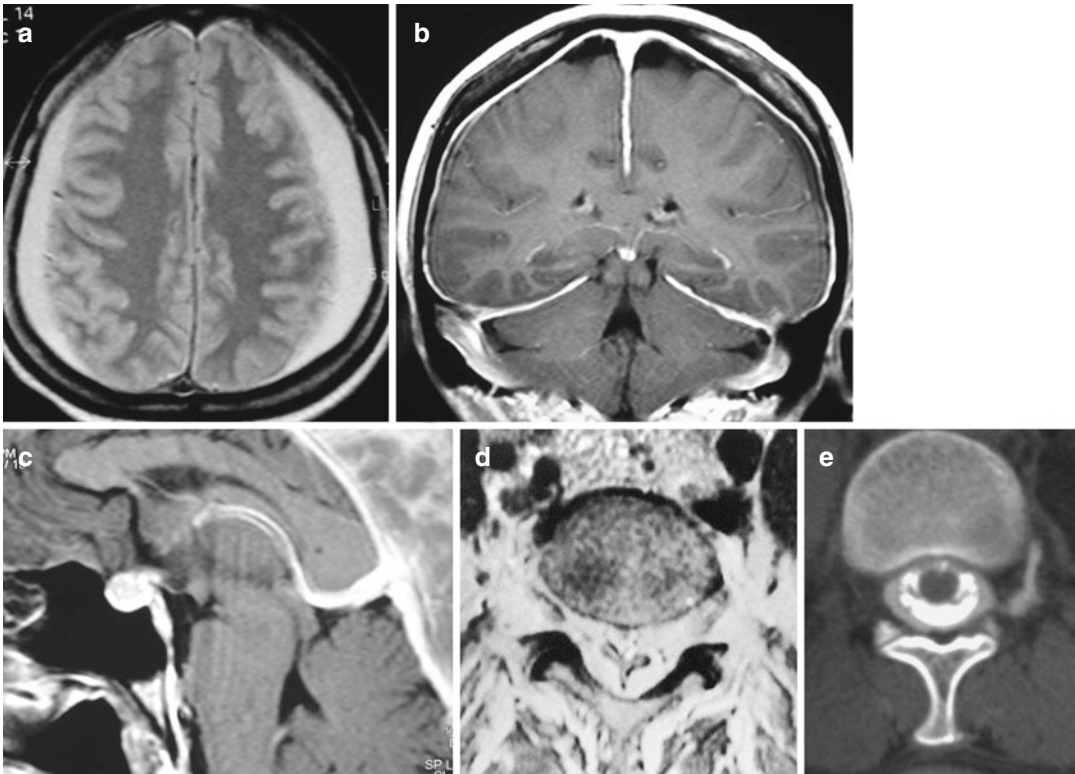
SIH. Axial T2-weighted image and coronal T1-weighted image after contrast medium administration (a) and (b) demonstrated bilateral subdural fluid collections (arrows) and diffuse dural thickening and enhancement along both cerebral convexities, the falx and the tentorium. Sagittal T1-weighted image with contrast
